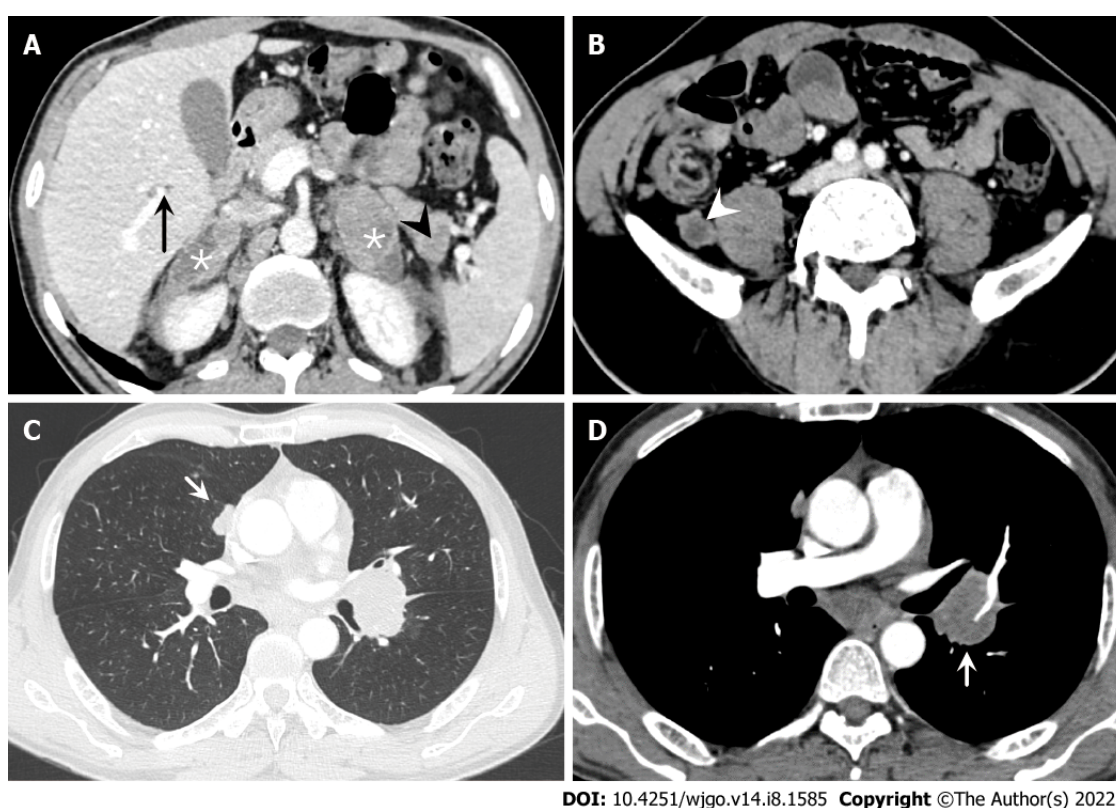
Abdominal and chest computed tomography. A: Multiple metastatic lesions are observed on the bilateral adrenal gland (*), liver (black arrow) and pancreas (black arrowhead); B: Several enlarged lymph nodes (white arrowhead) are seen on the retroperitoneal area; C: A pulmonary metastatic nodule (short white arrow) is seen in lung windows; D: Several enlarged lymph nodes (short white arrow) are shown on the mediastinum area in contrast-enhanced computed tomography.
